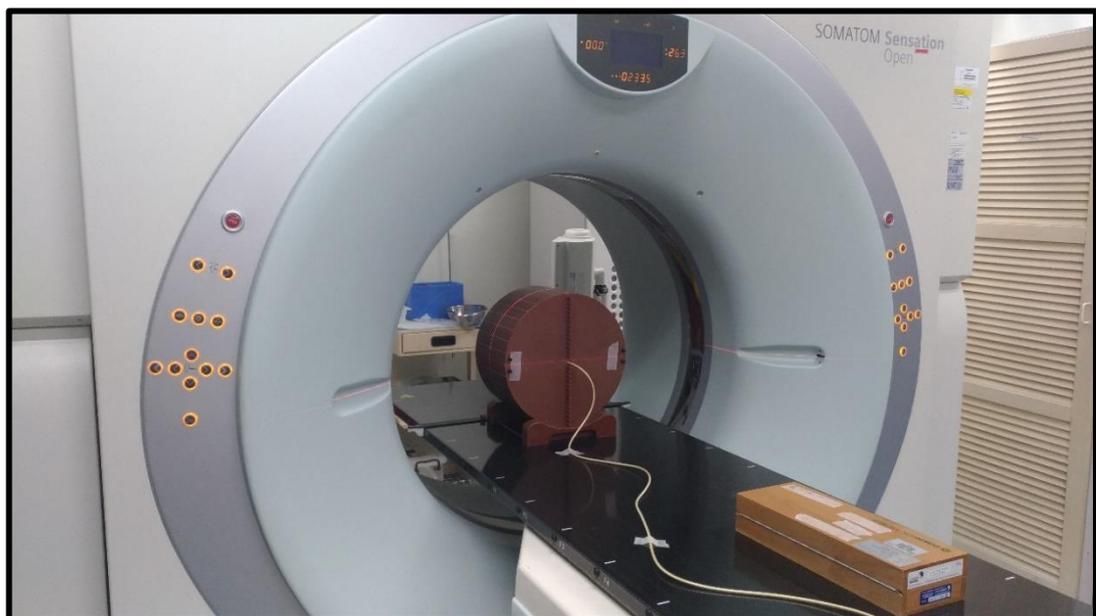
The Siemens Somatom Sensation Open CT Scanner with the experimental setup. [Courtesy of Mount Miriam Cancer Hospital]
